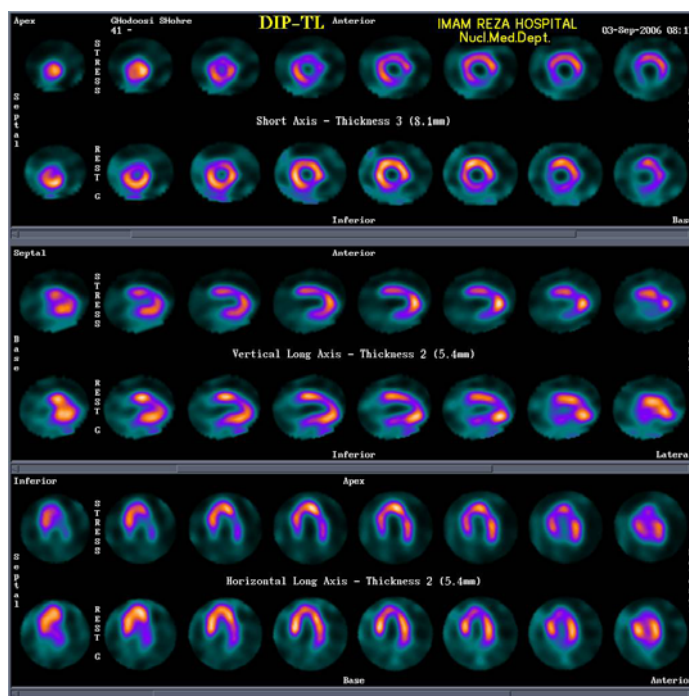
Processed images of ^{201}Tl SPECT of the patient.
